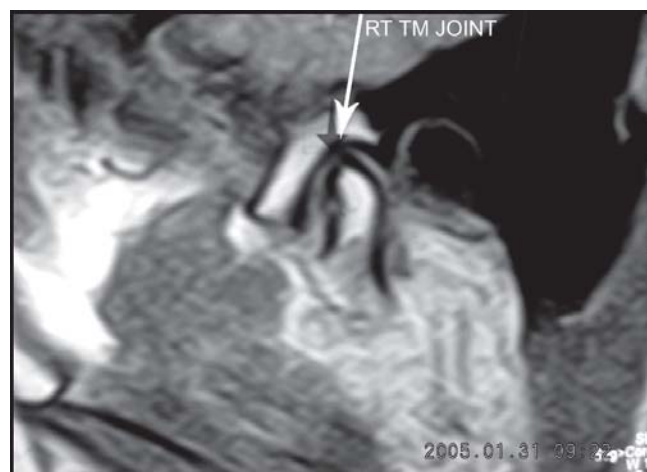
MRI of a TM joint in the sagittal plane
